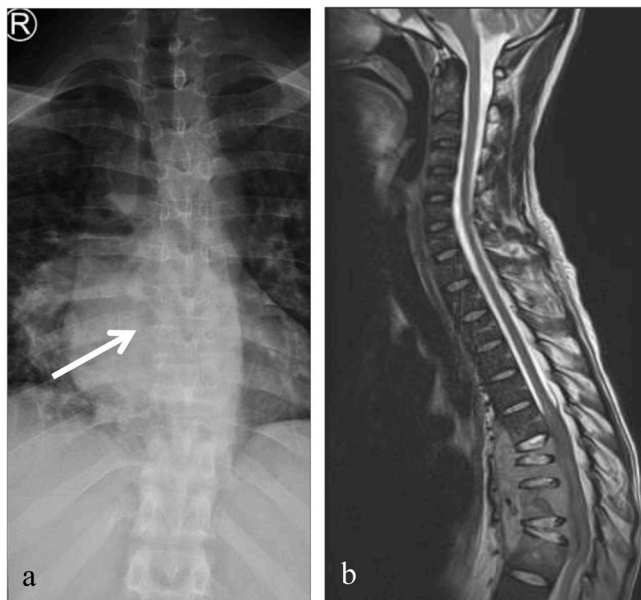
Spinal x-ray (a) and MRI (b) of the thoracic spine. Fig. 1a: The spinal x-ray taken between the first and second presentation raised the suspicion of 8th and 9th thoracic vertebra (white arrow) collapse. Interpretation was limited by the quality of the original x-ray and the absence of a lateral radiograph. Fig. 1b: Sagittal, T2 weighted MRI demonstrating infiltration at T6–T11 with spinal cord involvement and sparing of the intervertebral discs. Extensive mediastinal and subcarinal lymphadenopathy with a right para-hilar mass nodal complex with central breakdown was visualised (not shown). An adjacent right pleural collection and a small right sided pleural effusion were present. Although not classic, TB spondylodiscitis was considered as cause for the findings. Lymphoma was on the list differential diagnoses.
